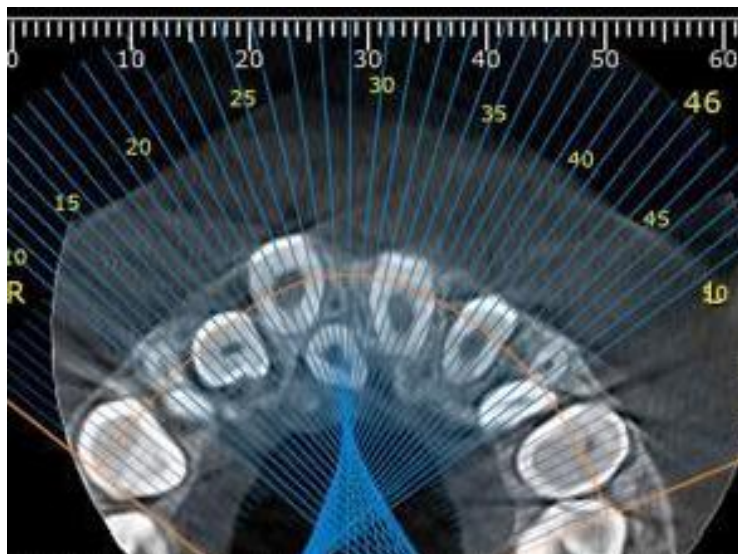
CBCT examination, axial section, showing the palatal position of the mesiodens and its relationship with tooth 1.1.
